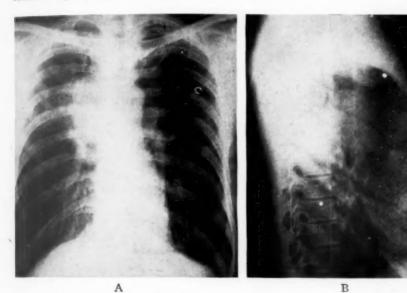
Case 5: A. Postero-anterior roentgenogram reveals mass in upper portion of right hilar region. Infiltration of the right upper lobe is evident.
